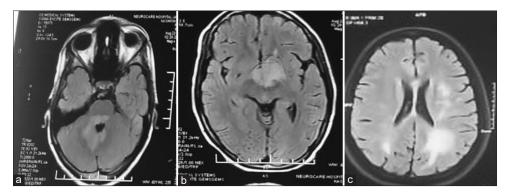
(a) MRI brain FLAIR sequence showing hyperintense signals in dorsal pons extending in right MCP and cerebellum. (b) MRI brain FLAIR sequence showing hyperintense signal in left hypothalamus. (c) MRI brain FLAIR sequence showing hyperintense signal in left subcortical periventricular area and corpus callosum in AQP-4 antibody positive patient
